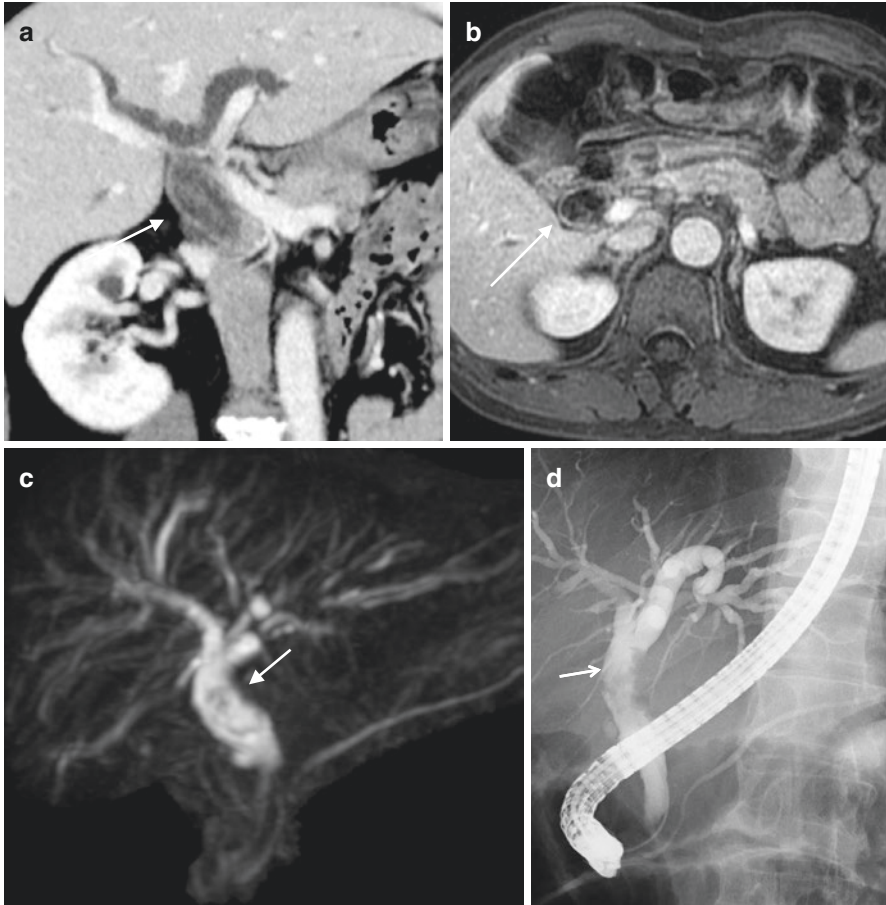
Imagings of intraductal papillary neoplasm of bile duct (IPNB) (60 year-old man with IPNB in common hepatic duct). (a) Contrast-enhanced computed tomography (CT) showing enhanced papillary tumor (arrow). (b) Magnetic resonance cholangiography (MRC) showing irregular filling defects with dilatation of up- and downstream of biliary duct (arrow). (c) Endoscopic retrograde cholangiography (ERC) showing irregular filling defects (arrow). (d) Cholangioscopic (CHF-B260; Olympus Corporation) findings showing papillary tumor located in common hepatic duct (arrows)
